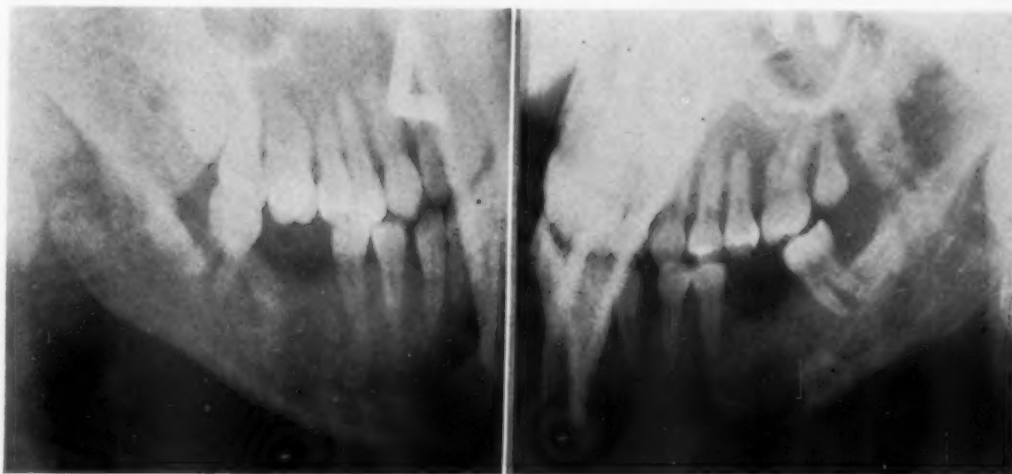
Roentgenograms of mandible five months after operation.
